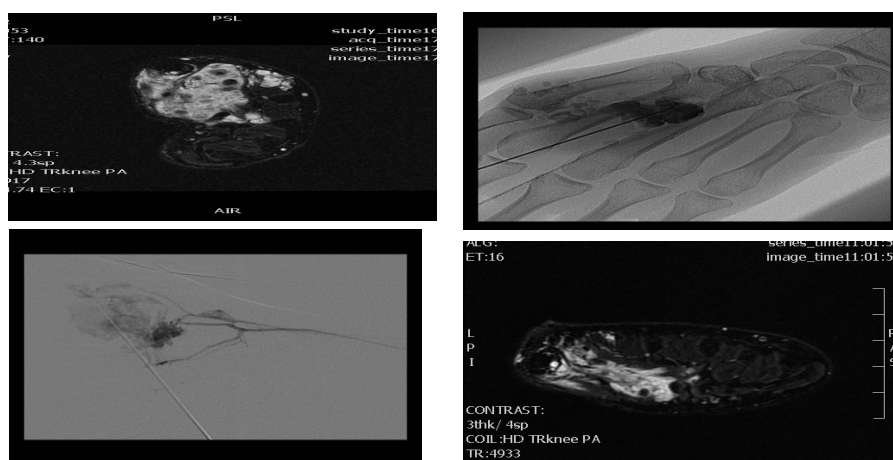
A. Axial MRI FSAT T2W image showing sizable thenar and hypothenar haemangioma. B. Percutaneous phlebography. C. DSA phlebography before embolization. D. Post embolization MRI showing significant reduction of haemangioma size.
